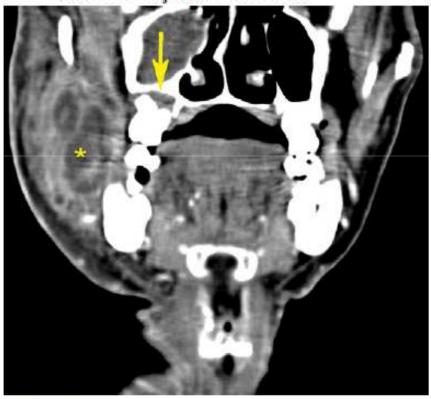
Masticator space infection. Coronal contrastenhanced computed tomography demonstrates right masticator space abscess (asterisk) originating from an odontogenic infection of the maxillary molar (arrow).
